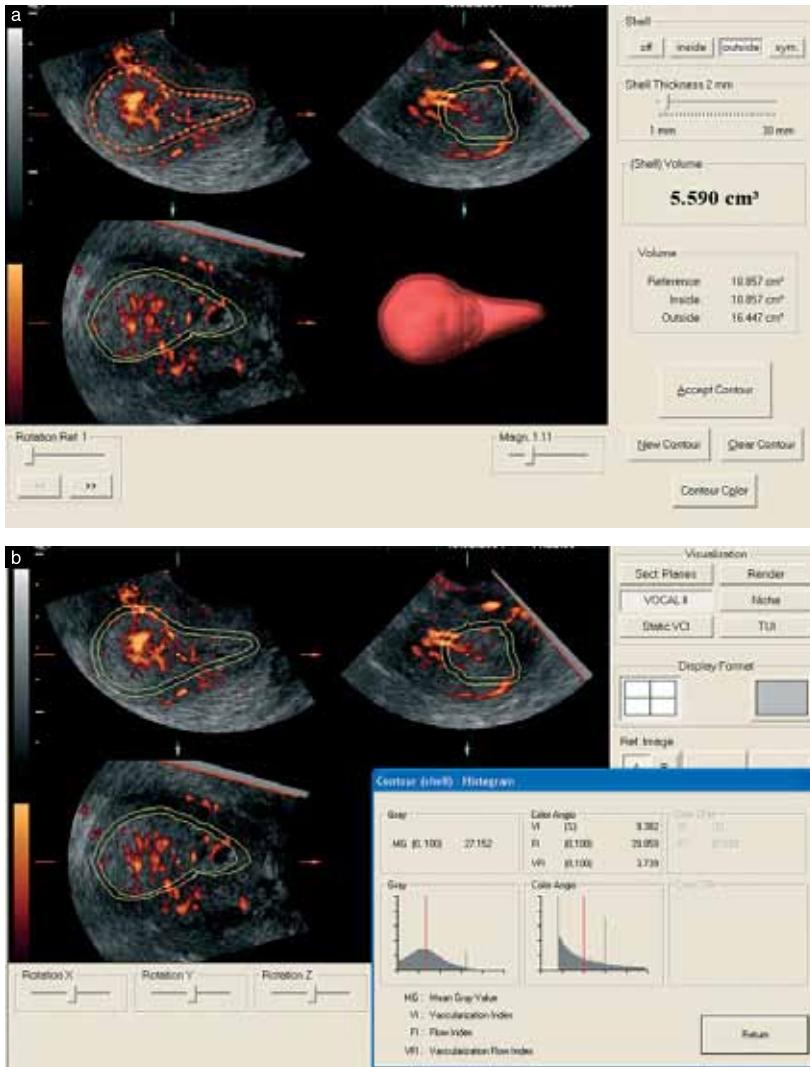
Calculation using VOCAL™ software of subendometrial volume, i.e. the 2-mm 'shell' surrounding the endometrium (a) and power Doppler indices (vascularization index (VI), flow index (FI) and vascularization flow index (VFI)) in the subendometrium (b).
